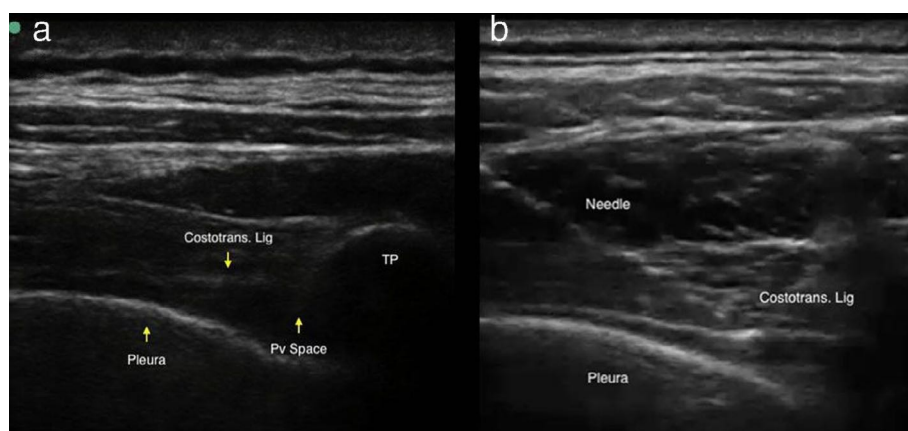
a. Ultrasound performed with a linear probe with longitudinal oblique, “in plane” technique demonstrating the paravertebral space. b. Demonstration of needle trajectory for t-PVB. [Color figure can be viewed at wileyonlinelibrary.com]
